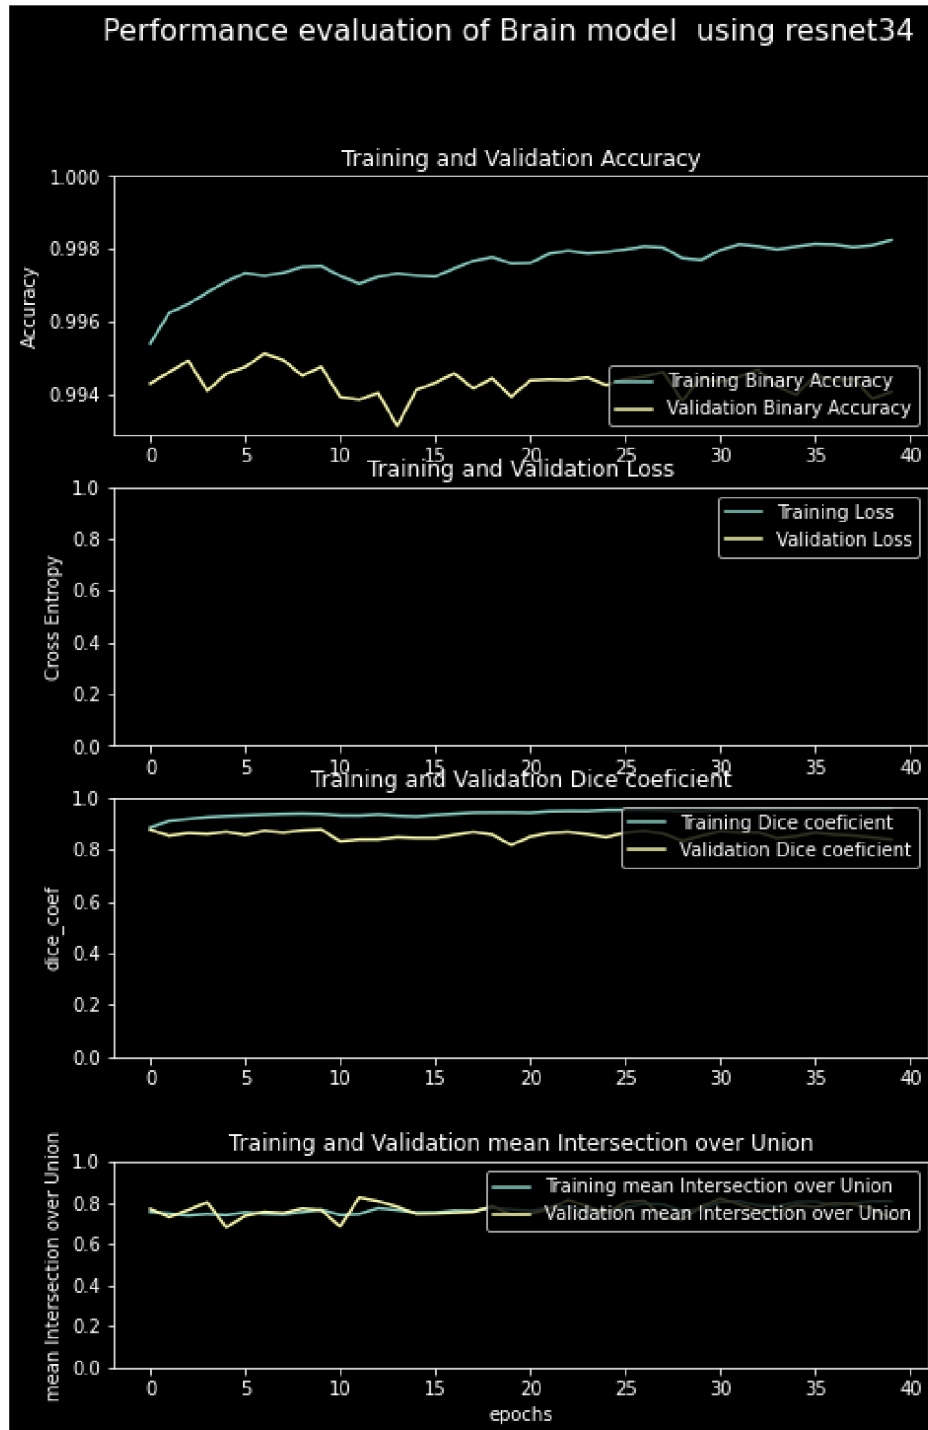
Performance of the custom u-net model using Resnet34 backbone on Brain MRI images. Note the epoch (abscise) graduation with 1 unit = 5 epochs to show the different intersections of the learning and validation curves due to the gradual change in the learning rate up to 0.0001. (Own work)
